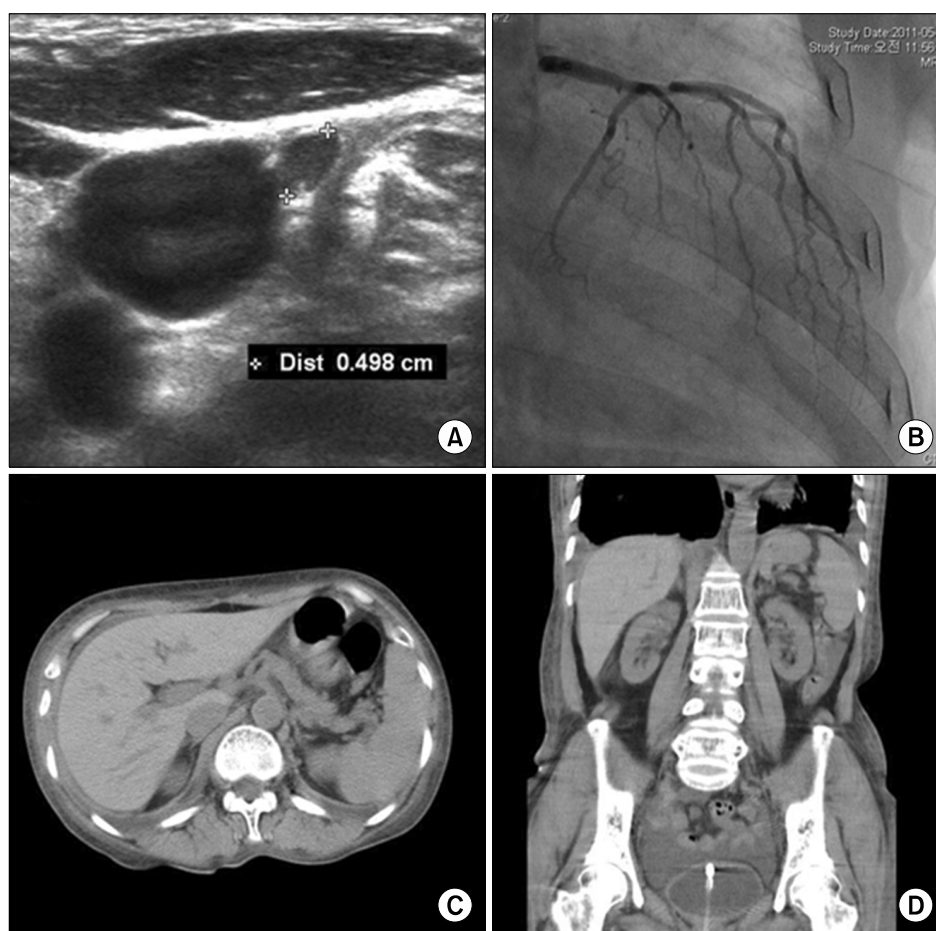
(A) On a thyroid ultrasonography for primary hypothyroidism, diffuse enlargement and a small cystic lesion were observed with no other abnormalities. (B) A coronary angiography for frequent polymorphic VT along with serum cardiac enzymes increasing as high as several folds of normal ranges showed no abnormalities of LCA, LCX, RCA and their branches. as for the renal failure and hyporeninemic hypoaldosteronism, a computed tomography scan revealed that the adrenal glands were normal in size with no mass (C) and the both kidneys were shrunk with no mass or lesion, indicating that it may be a chronic nephropathy (D).
